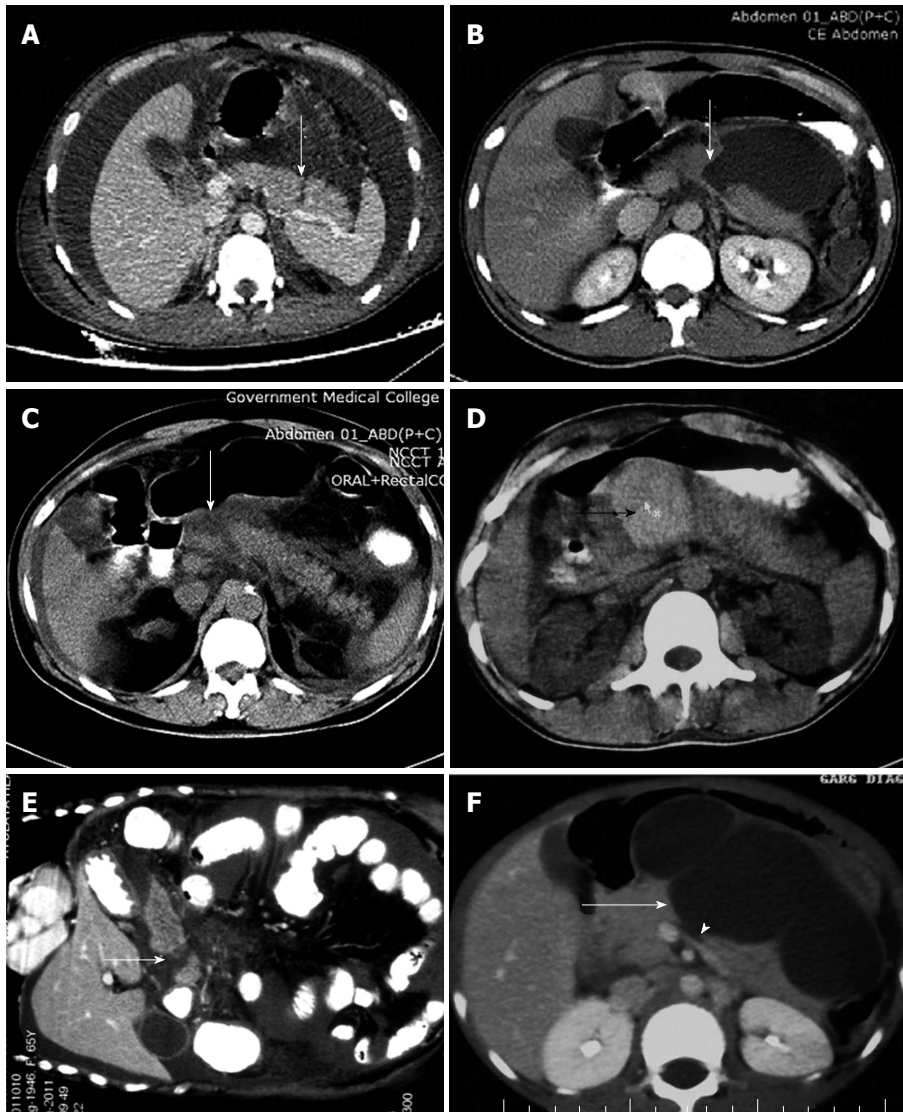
Computed tomography images.
